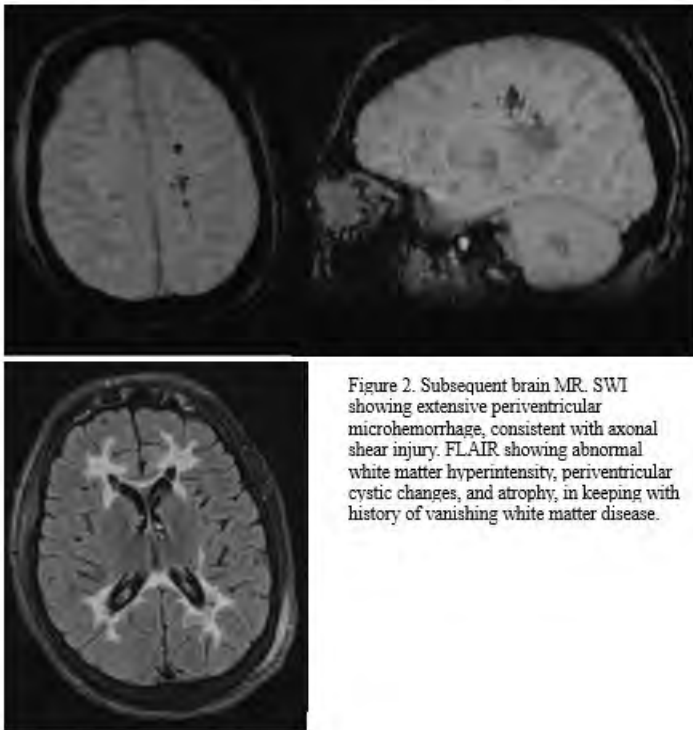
Subsequent brain MR. SWI showing extensive periventricular microhemorrhage, consistent with axonal shear injury. FLAIR showing abnormal white matter hyperintensity, periventricular cystic changes, and atrophy, in keeping with history of vanishing white matter disease.
